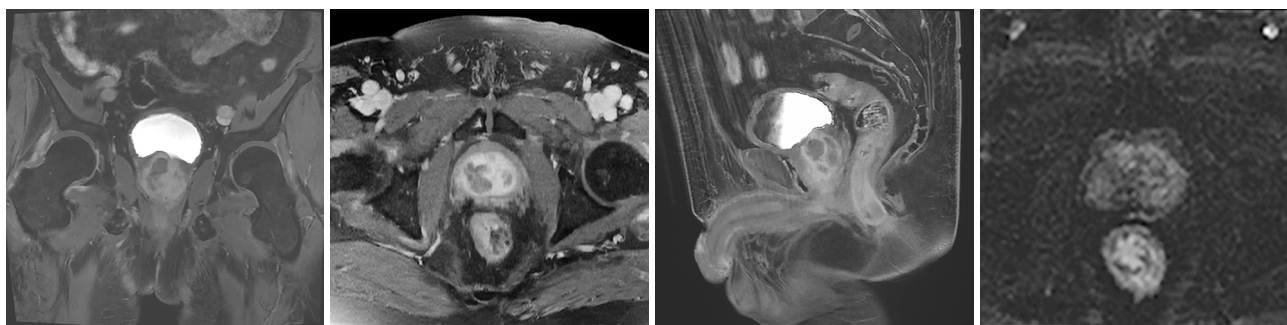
MRI findings one year after the surgery: PV was approximately 2.8 cm × 2.3 cm × 2.1 cm, soft tissue mass shadow was not obvious anymore, and the region with high signal intensity (DWI) disappeared. MRI, magnetic resonance imaging; DWI, diffusion-weighted imaging; PV, prostate volume.
